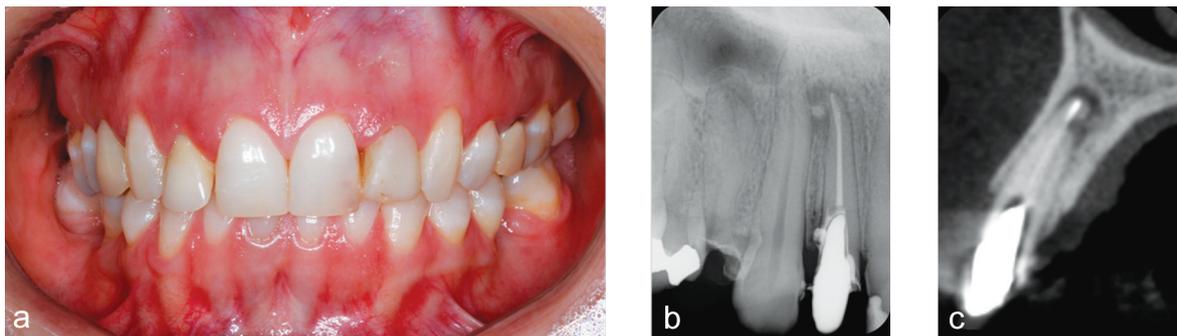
Case 1 in the preoperative phase: initial clinical aspect (a); preoperative periapical radiograph (b); CBCT (c).
